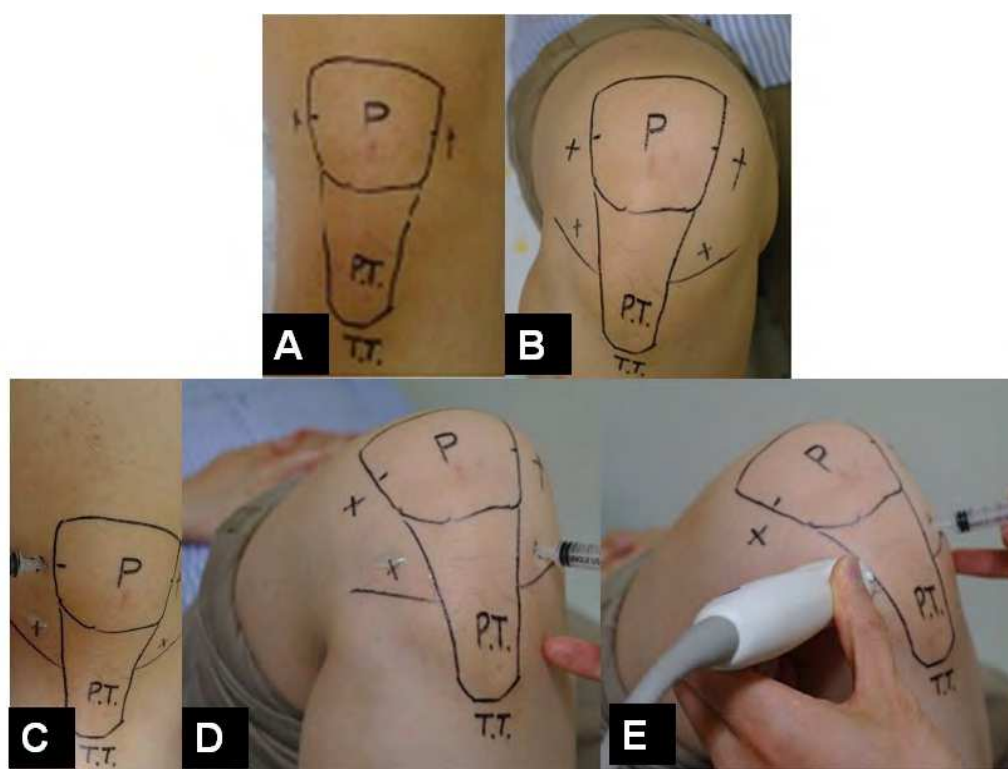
All landmarks were outlined with a marking pen. A. Landmarks for lateral and medial mid-patellar injections sites. B. Landmarks for anteriomedial and anteriolateral injections sites. C. Lateral mid-patellar injection were performed with the lower limb extended on the examination table. D. Anteriolateral injection were performed with the knee in flexed position. E. Anteriolateral injection via ultrasound guidance were performed with the knee in flexed position.
